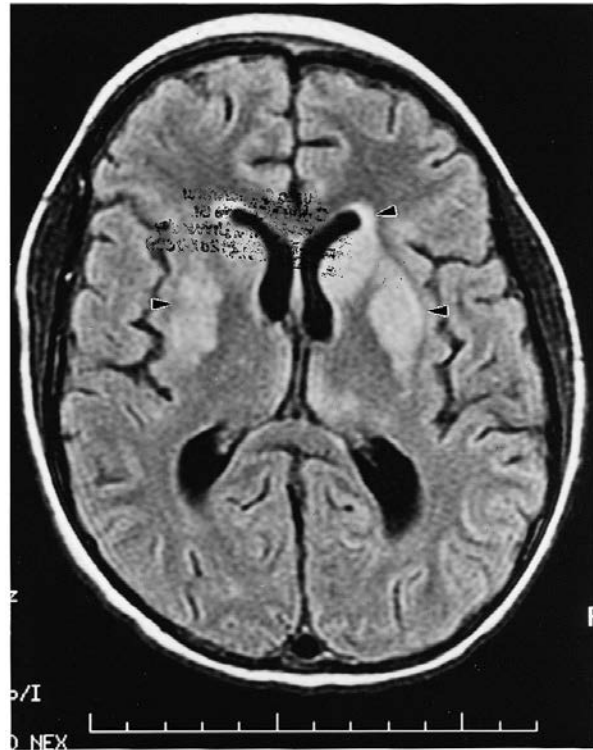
MRI in cerebral lupus. Hyperintensities (arrowheads) in the left basal ganglion and right internal capsule.
